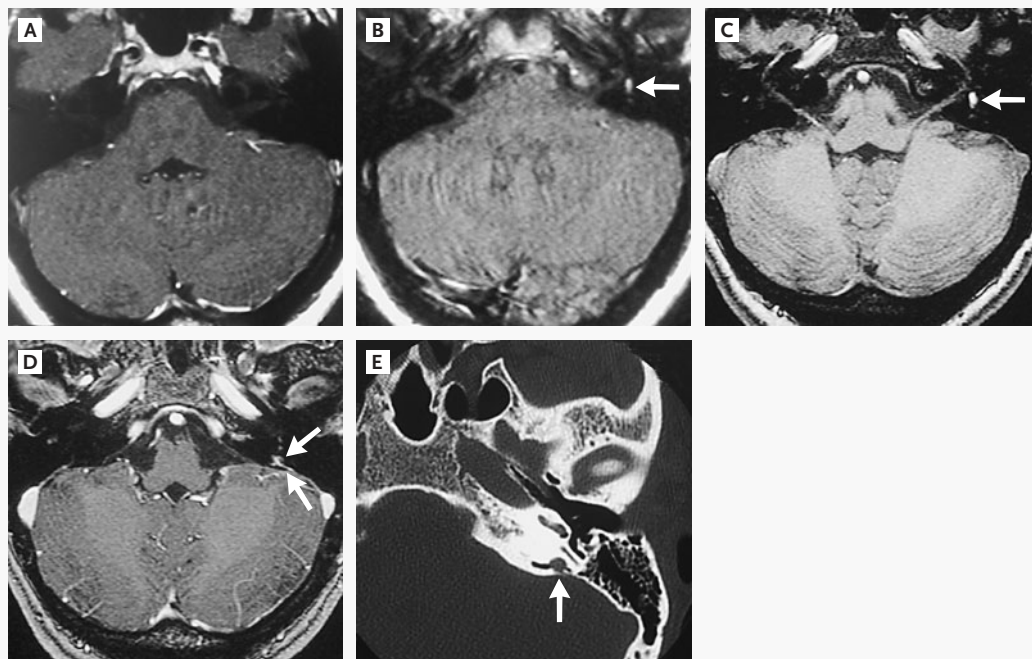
MRI and CT Scans of the Temporal Region in Patient 3.
